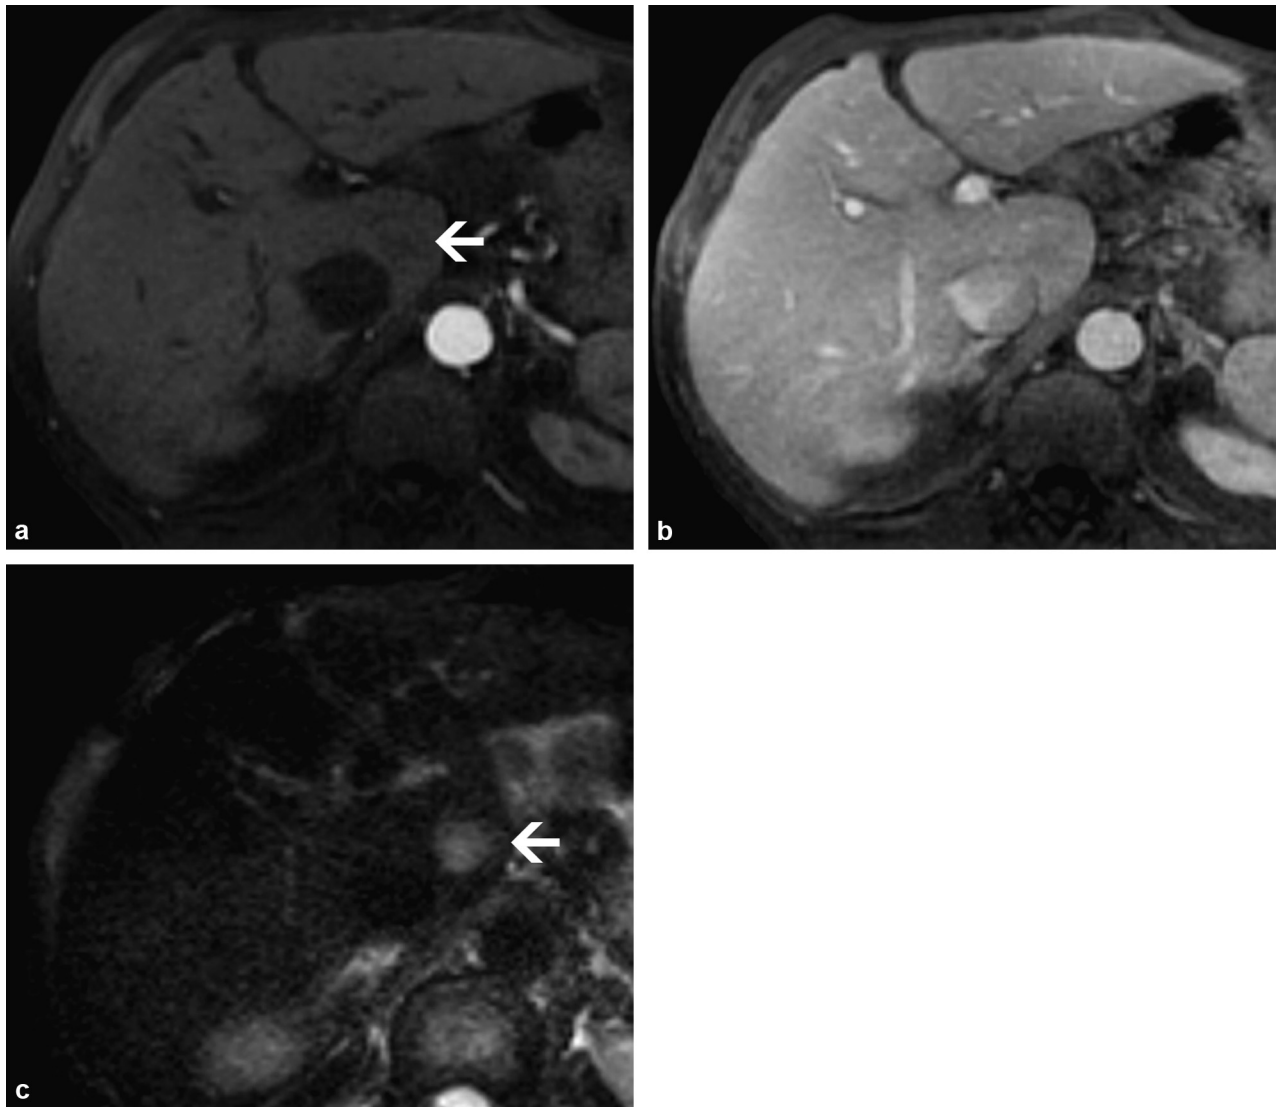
Hypovascular hepatocellular carcinoma (HCC). Monitoring examination for cirrhosis of exogenous origin. T1-weighted MRI with fat saturation in the arterial (a) portal (b) phases and diffusion-weighted sequence (c). The HCC is hypovascular but hyperintense in the diffusion-weighted sequence (arrow).
